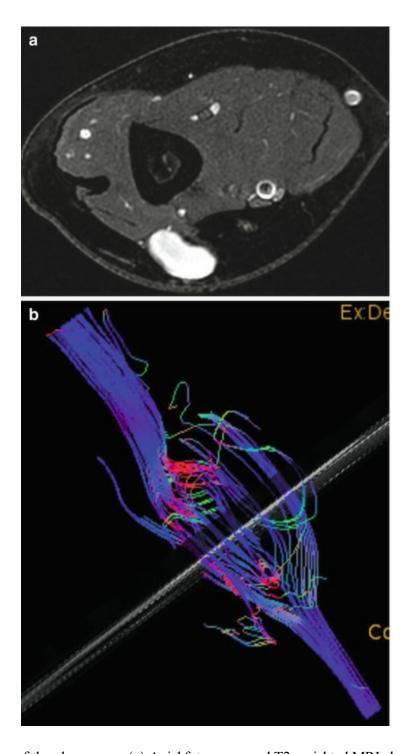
Schwannoma of the ulnar nerve. (a) Axial fat-suppressed T2-weighted MRI shows the nerve is enlarged and hyperintense. (b) Tractography shows disorganization of the nerve fibers
